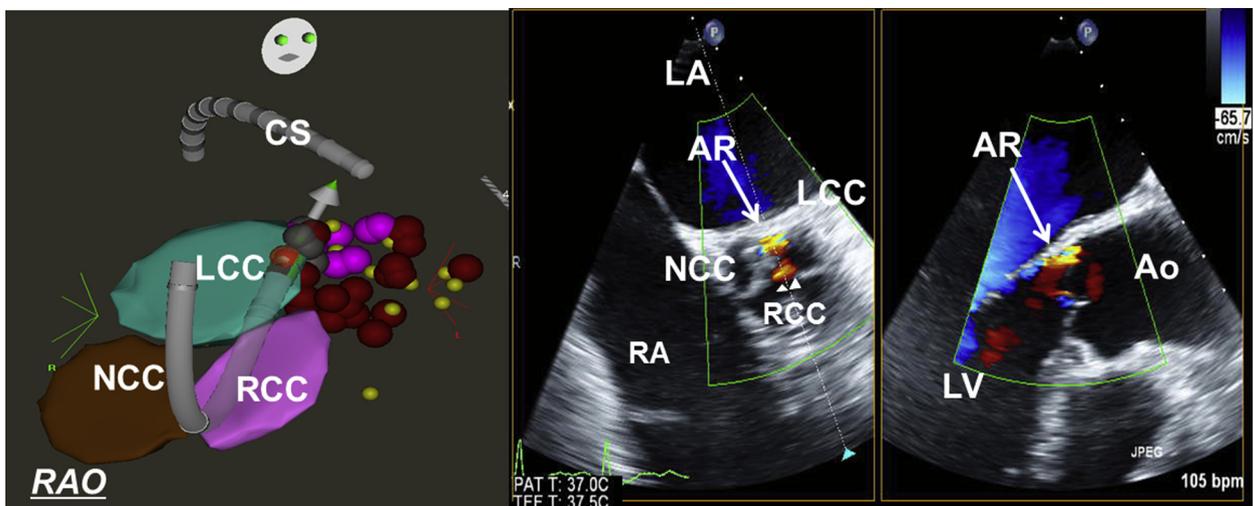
A case of AR at the LCC-NCC commissure. A: Patient 1: A 3-dimensional anatomic mapping with an intracardiac echocardiography system shows that the location of radiofrequency applications was above and below the LCC-RCC junction. In addition, the ablation catheter was inserted into the LV through the NCC-RCC commissure. B: AR at the center of the aortic leaflets (arrow head) and NCC-LCC commissure (arrow) was observed on transesophageal echocardiography 1 day after the ablation procedure. Ao = aorta; AR = aortic regurgitation; CS = coronary sinus; LA = left atrium; LCC = left coronary cusp; LV = left ventricle; NCC = noncoronary cusp; RA = right atrium; RAO = right anterior oblique; RCC = right coronary cusp.
